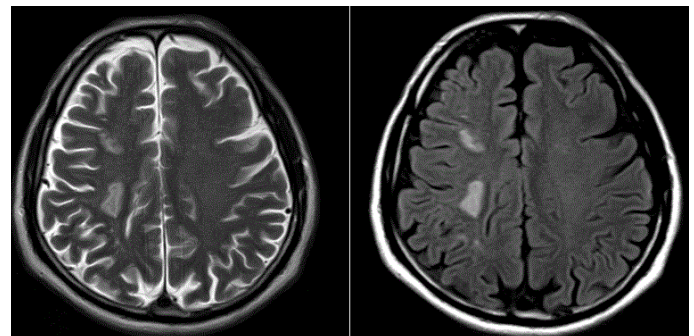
Magnetic resonance imaging of T2 weighted and flair image of the brain.
